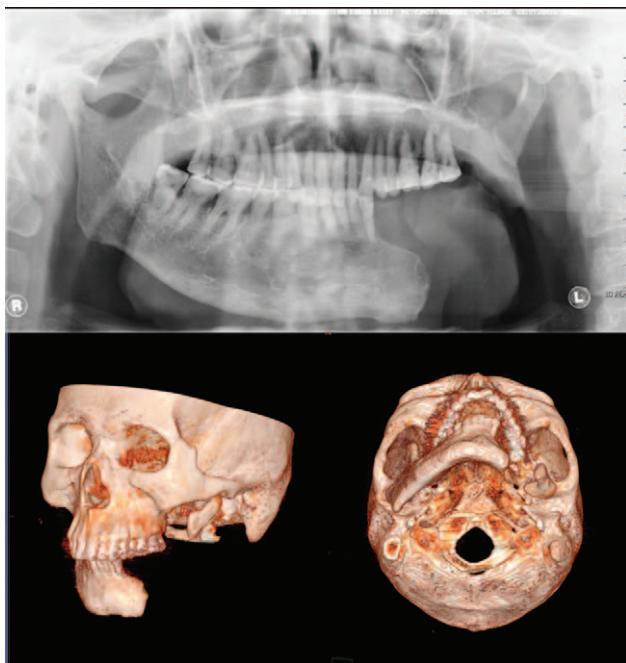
Preoperative panoramic radiograph and 3-dimensional imagings of the patient show a mandibular defect involving the left mandibular body and ramus.
